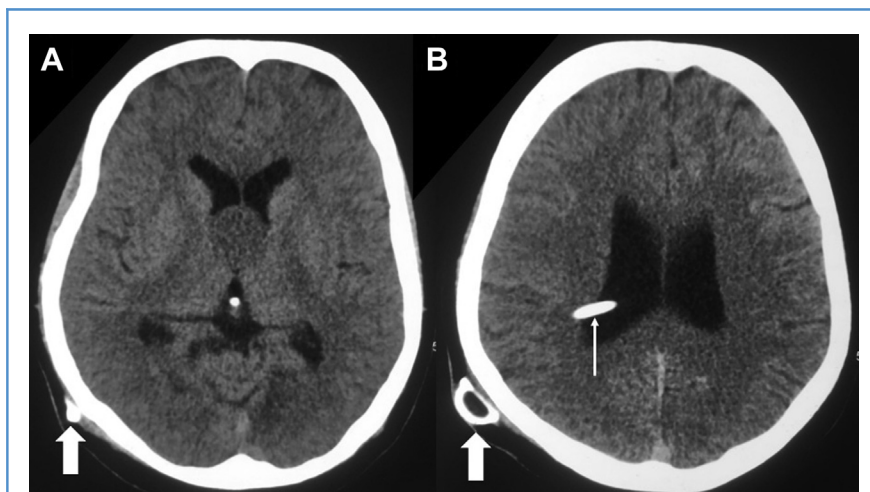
(A and B) CT brain plain post ventriculo-peritoneal shunt image 1. (A) A well defined hypodense spherical lesion is seen in the region of Foramen of Munro. Note the shunt chamber (Thick white arrow) in the right posterior parietal region (A and B). (B) The ventricular end of the shunt catheter is seen in the right lateral ventricle.
